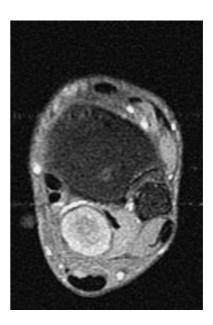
A 42-year-old male presented with tarsal tunnel syndrome. The T1 axial MRI-scan showed a posteromedial mass. This lesion was found to be a nerve sheath tumour.
